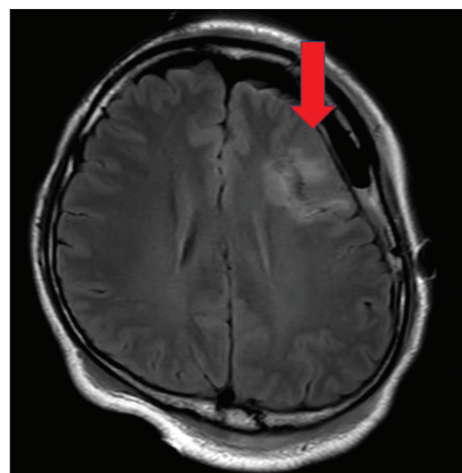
Postoperative magnetic resonance imaging showing total tumor removal. T2 fluid-attenuated inversion recovery high signal intensity area remained, which has been suggested as brain edema (arrow).
